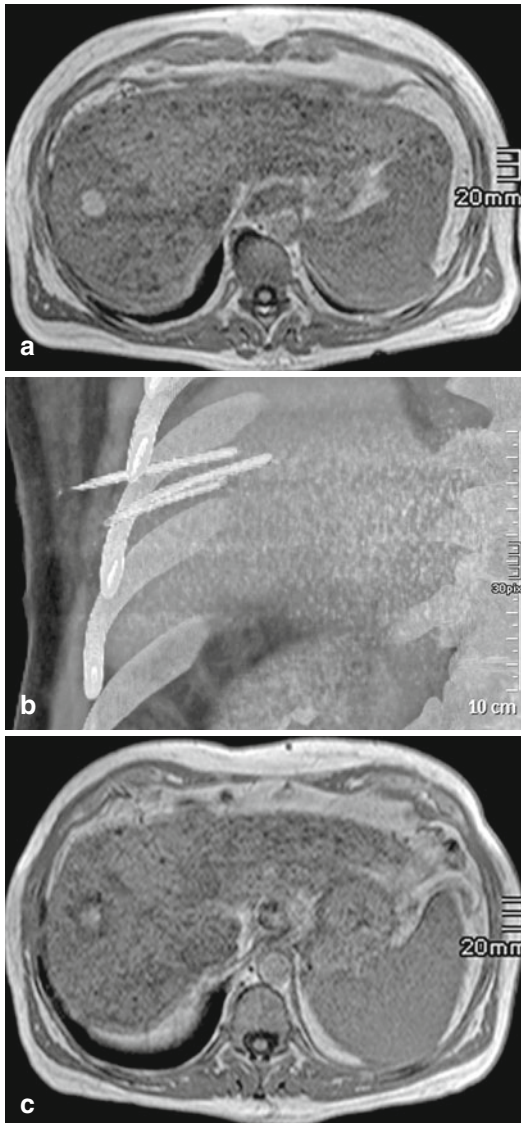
IRE in a patient with liver cirrhosis and hepatocellular carcinoma (HCC): the initial MR imaging shows a hyperintense lesion in the in-phase FFE image (a). Volume-rendered image computed from CT data obtained during the procedure shows three electrodes in the tumor (b). The post-interventional MR imaging 3 weeks after IRE shows the IRE area as a hyperintense lesion in the in-phase FFE image (c). It already decreases in size. The lesion is surrounded by a hypointense rim of reactive changes
